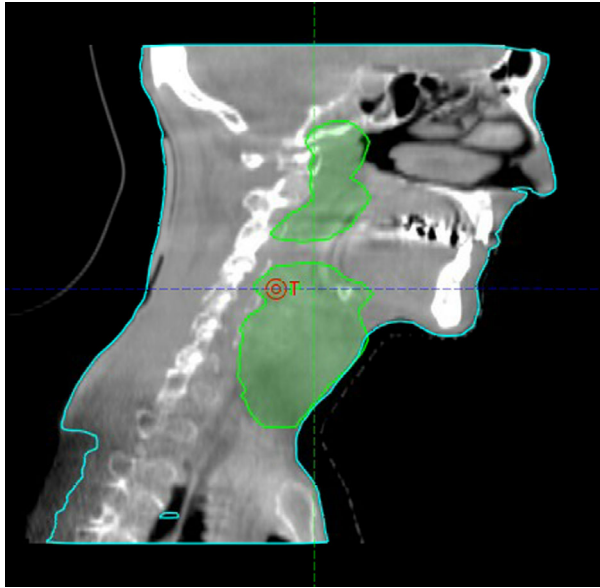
Sagittal view of CBCT taken on the 10th fraction.
